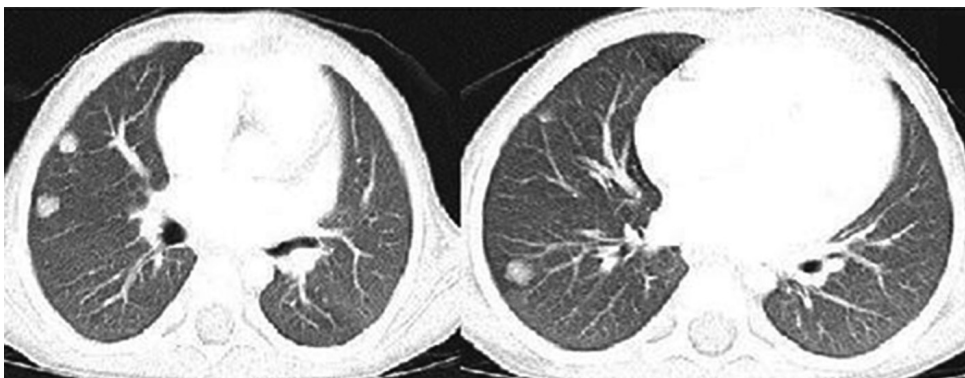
Computed tomography sections showing multiple lesions in both lungs.
